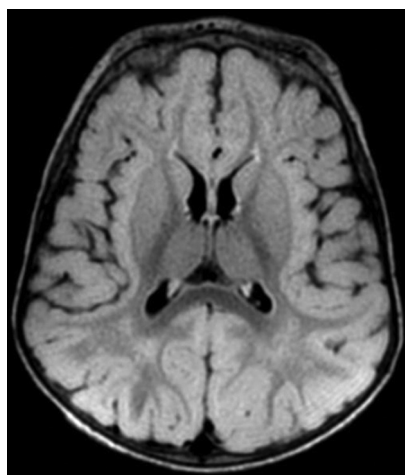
Brain magnetic resonance imaging of the patient
